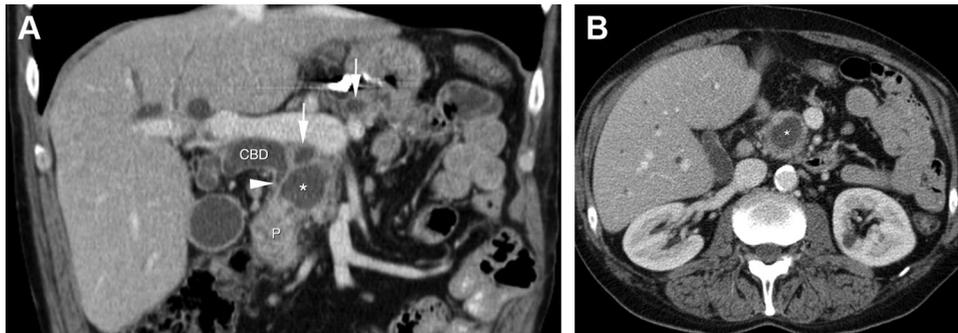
Focal chronic pancreatitis and pseudocyst. A 60-year-old man with focal chronic pancreatitis and pseudocyst. The original radiologist described a cystic pancreatic tumor suspicious for malignancy. Both expert radiologists interpreted this as a pseudocyst in chronic pancreatitis. (*A*) Coronal reformatted CT image depicts a cystic lesion (*asterisk*) in pancreatic head (P) with dilated pancreatic duct (*arrows*) and common bile duct (CBD), which tapers (*arrowhead*) in proximity of the pseudocyst. (*B*) Axial CT image showing the pseudocyst (*asterisk*) in pancreatic head.
